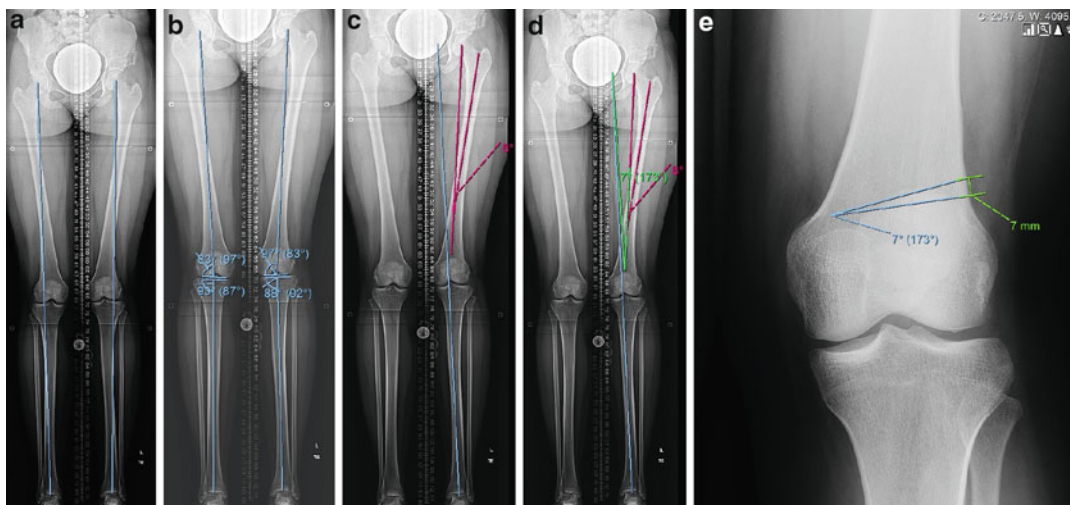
(a) Standing X-ray shows bilateral lateral mechanical axis deviation (*MAD*). (b) Joint orientation angles demonstrate that the deformity is coming from the femurs. The LDFAs are 83° . The MPTAs are normal at 87° and 88° . (c) Surgical planning: Step 1, draw a line (*blue*) from center ankle through medial tibial spine and extend to hip level to where femoral head should be after correction. Step 2, draw an anatomic axis line (*pink*) and a 6° mechanical axis line (*pink*) from
